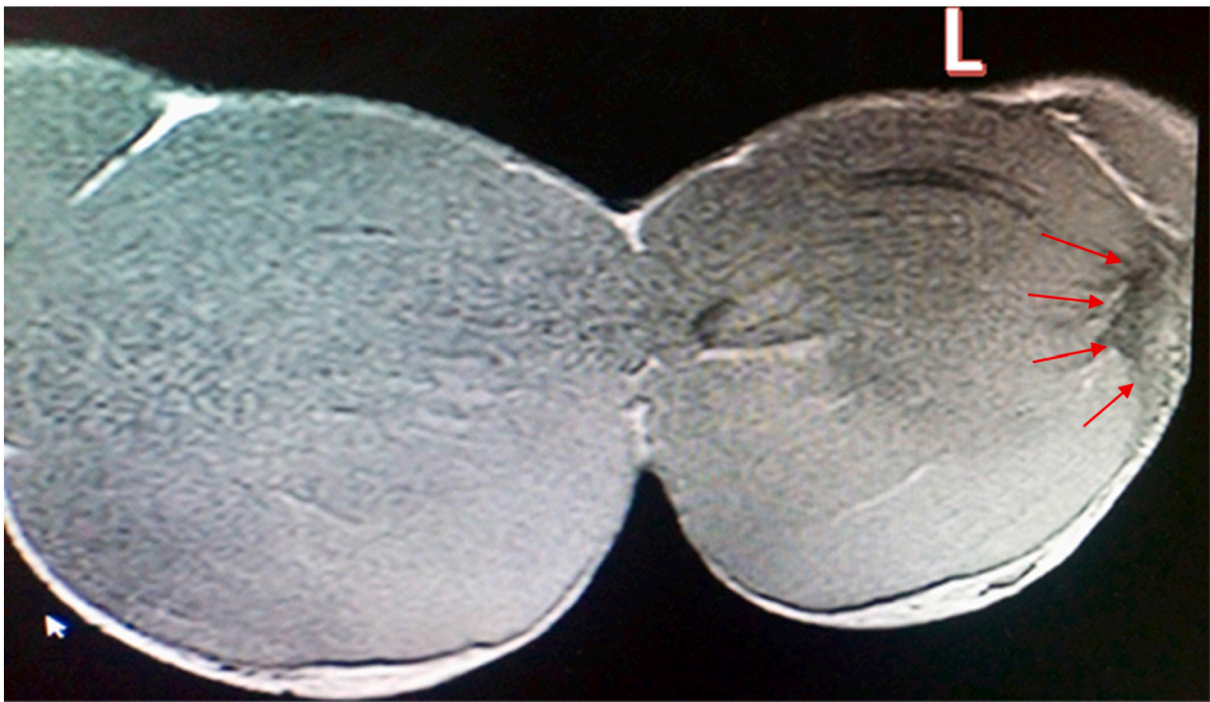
Coronal MRI T1 shows the clear tear in the musculotendinous junction of the sterno-costal part of the left Pectoralis Major muscle in comparison to the right one (red arrows). (For interpretation of the references to colour in this figure legend, the reader is referred to the web version of this article.)
